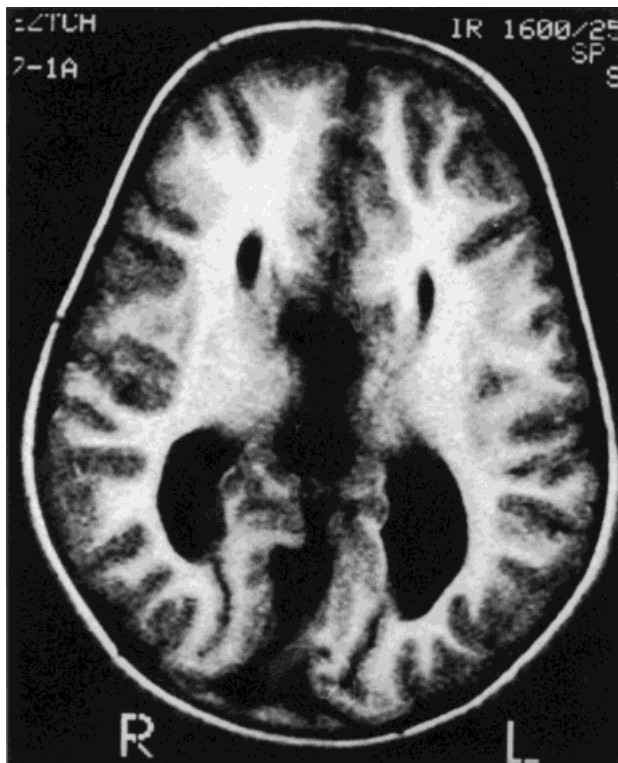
Cranial MRI scan of the son.
